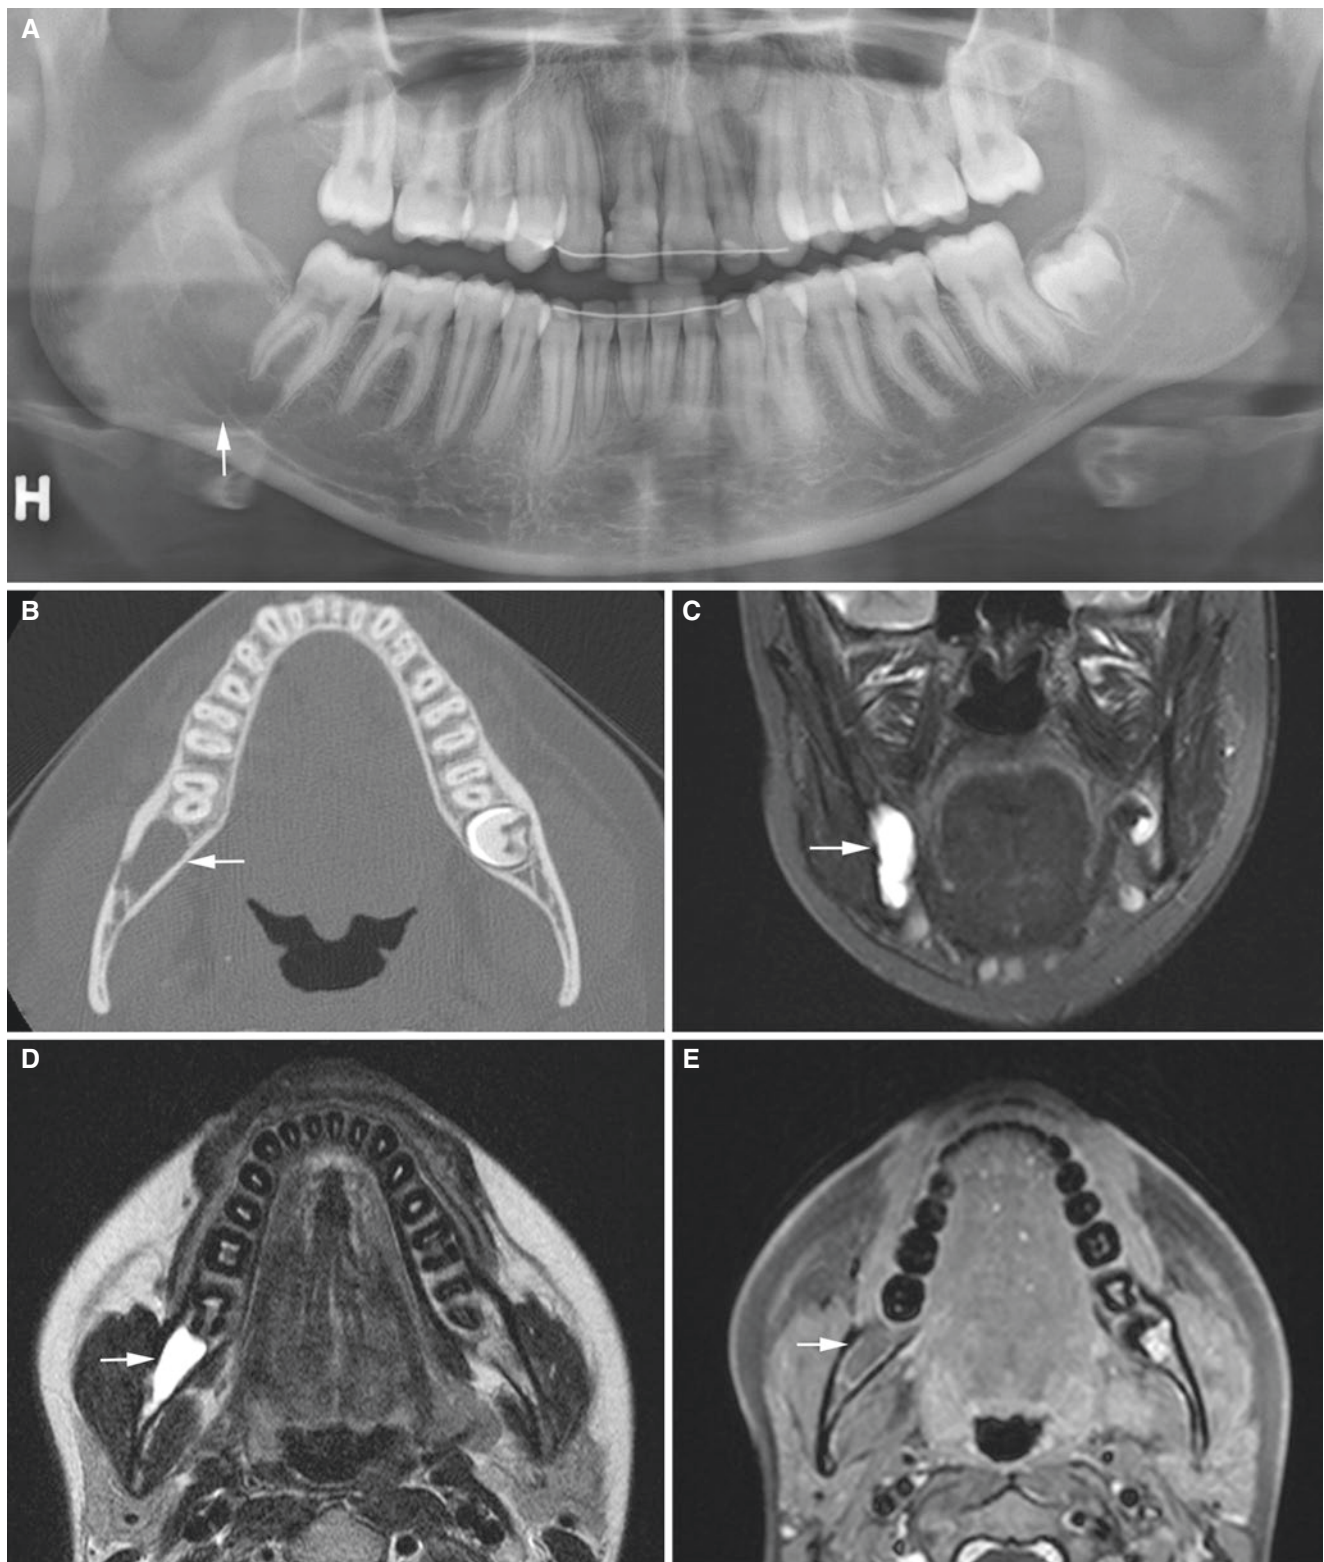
Simple bone cyst, mandible; 15-year-old female, incidental finding. (A) Panoramic view shows radiolucency in retromolar area of the right mandible (*arrow*). (B) Axial CT image shows radiolucency without buccal or lingual expansion (*arrow*). (C) Coronal STIR and (D)
